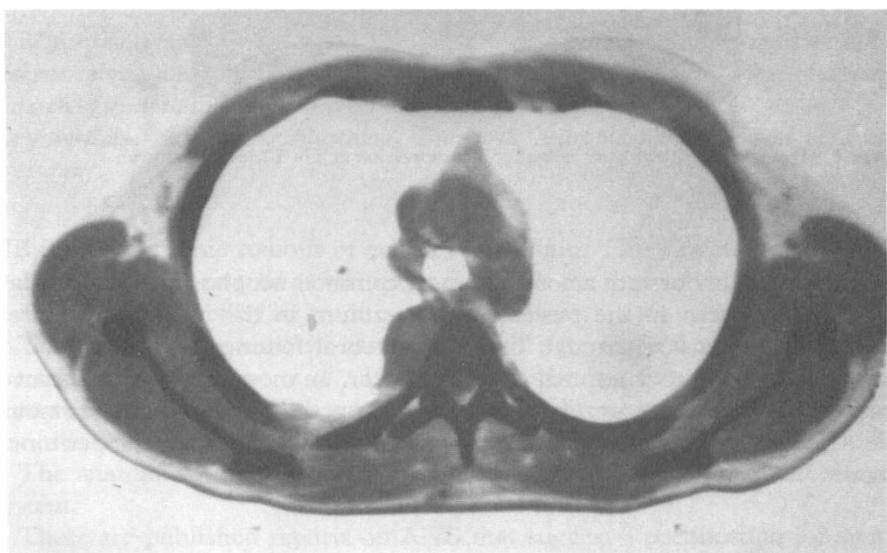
CT Scan showing a right paraspinal mass and a little pleural effusion.
